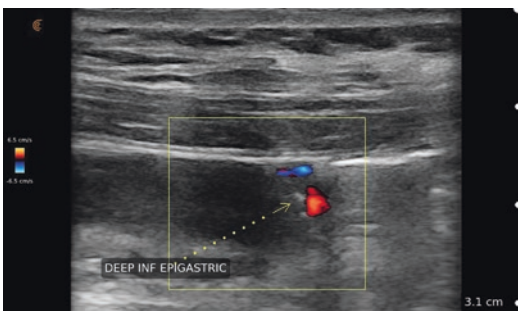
Color Doppler ultrasound image of abdominal wall. Transducer is oriented longitudinally over the rectus muscle below the umbilicus. The deep inferior epigastric artery and vein are seen just below where they enter the rectus abdominis muscle
